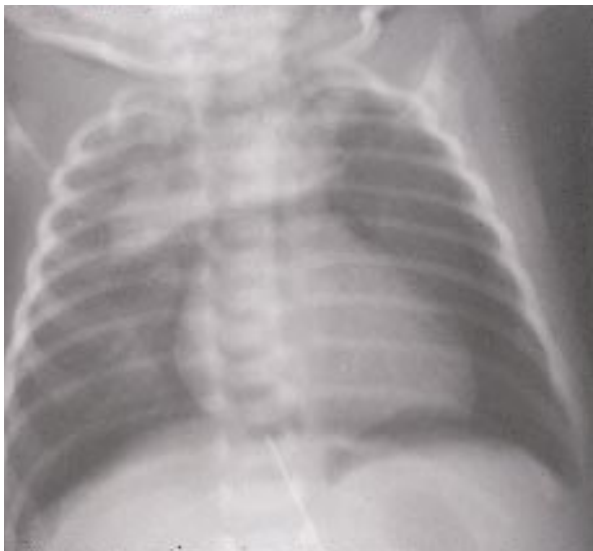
Radiograph of the chest in an infant requiring resuscitation at delivery. Note the pneumomediastinum with the lobes of the thymus gland being very prominent bilaterally ("butterfly wing" appearance) as a result of the air in the pneumomediastinum lifting up the lobes of the thymus.
